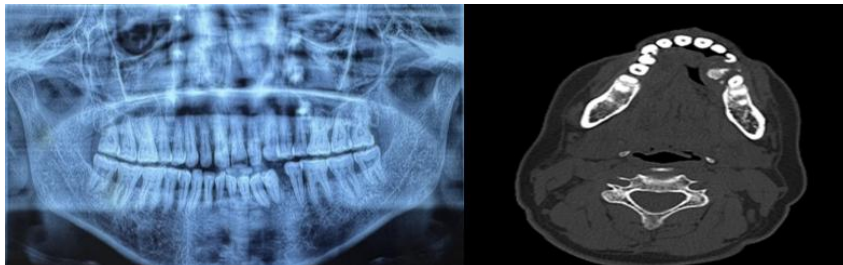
A- Orthopantomogram evaluation showed the presence of pathological migration of 33, 34. B- Computed Tomography scan revealed, ill-defined lesion measuring with calcification along the mandibular left lingual alveolus without root resorption. Expansion of lingual and buccal cortex of mandible noted.
